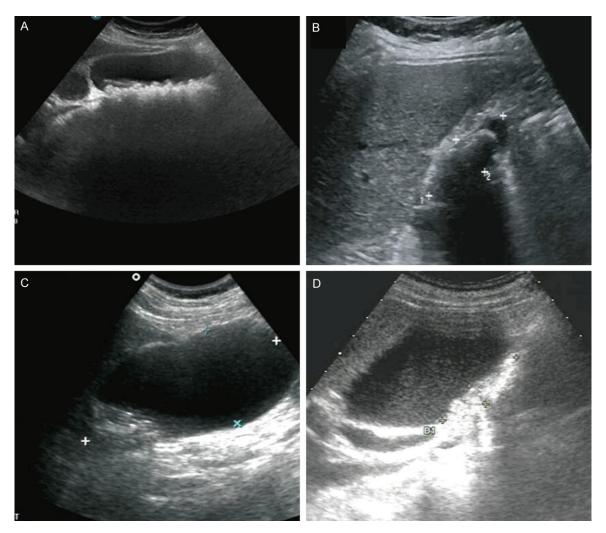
A. Preoperative ultrasound examination shows gallbladder enlargement and multiple cholecystolithiasis; postoperative pathological examination shows moderately differentiated adenocarcinoma at the bottom of the gallbladder that infiltrated to the muscular layer of gallbladder wall. B. The patient has no symptoms; however, ultrasound examination during routine physical examination shows cholecystolithiasis and atrophic gallbladder; pathological examination shows that the thickness of the gallbladder wall was 3-5 mm, moderate to poorly differentiated adenocarcinoma, and infiltration of all the layers of the gallbladder wall. C. The patient is diagnosed with incarcerated calculi at the gallbladder neck and acute cholecystitis; pathological examination shows poorly differentiated adenocarcinoma with liver partially. D. The patient is diagnosed as cholecystolithiasis with enlarged gallbladder; pathological examination shows moderately to poorly differentiated adenocarcinoma at the gallbladder body.
